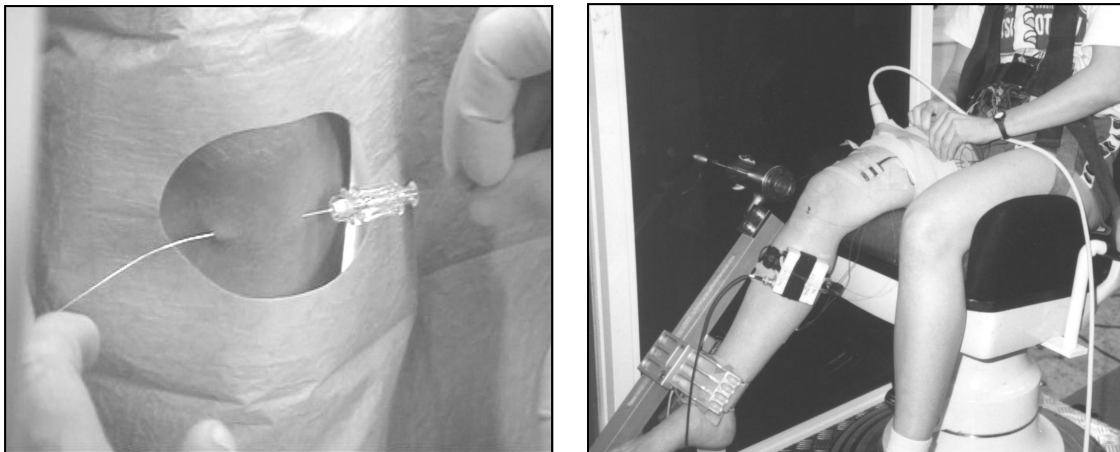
An optic fiber force transducer has been passed through patellar tendon with a help of a hollow needle (left). After the needle has been removed the fiber remains in situ. On the right, a subject is sitting in the knee extension device during calibration of the tendon force transducer. A little amount of blood is coming out of the insertion site near the patellar tendon. The tips of the fiber have been attached to the light transmitter-receiver unit that is fixed to the subject's shank. An ultrasound probe has been secured to the subject's thigh for fascicle length measurements. Knee extension force was measured with a strain gauge in the lever arm of the ergometer.
